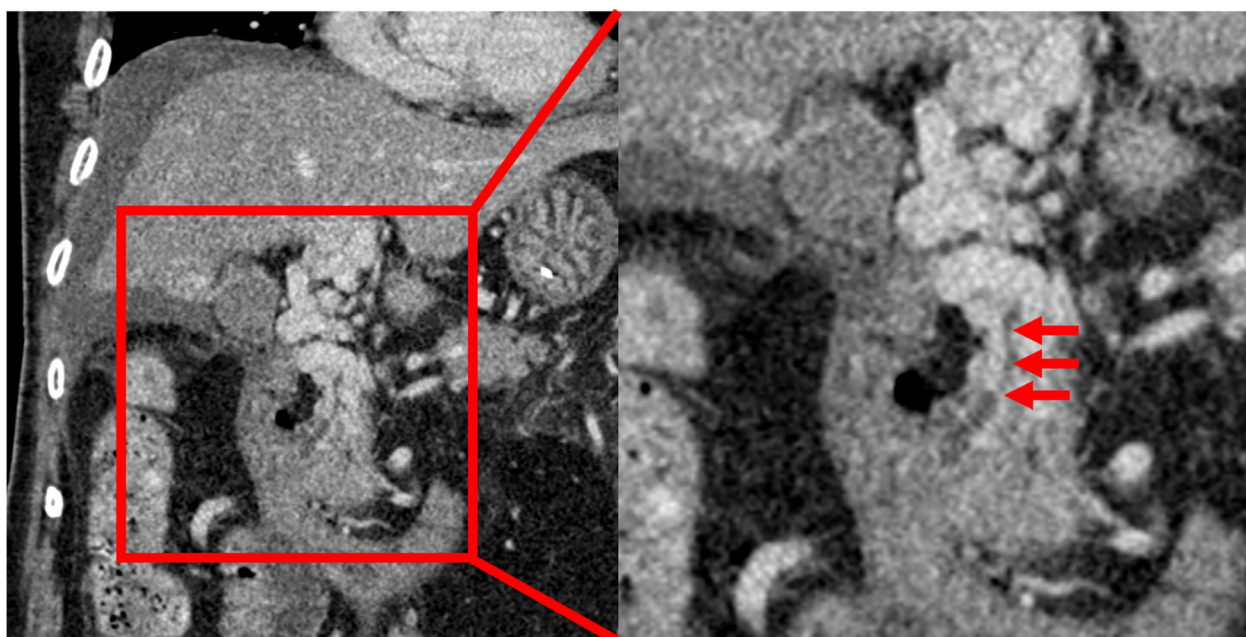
Coronal reconstruction CT scan through the common bile duct in the portal venous phase. The common bile duct (→) was directly compressed by the portal cavernoma.
